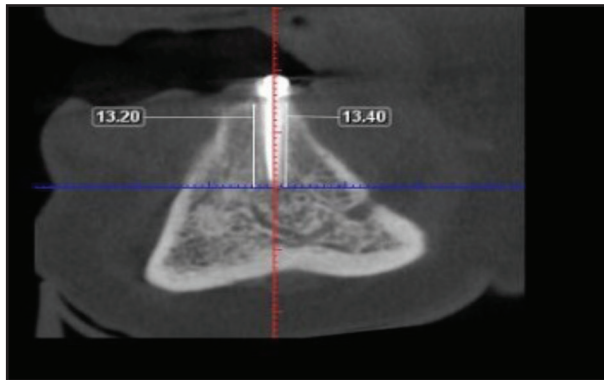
CBCT radiograph for bone height measurement
